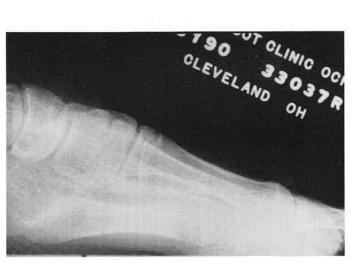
Preoperative dorsoplantar x-ray of a patient with a calcaneonavicular coalition presenting in adolescence. A significant degree of pes planus deformity was present, along with peroneal muscle spasm.
